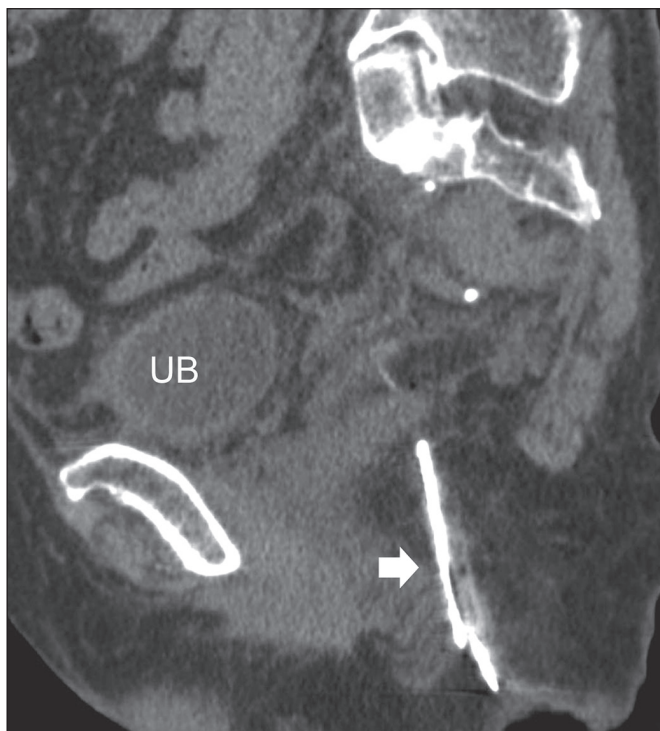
An 88-year-old woman with a bamboo splinter penetrating the right gluteal muscles after a fall. Sagittal reconstructed CT image delineating the full size of the FB (thick arrow) deeply impacted in the soft tissue. (UB, urinary bladder).
